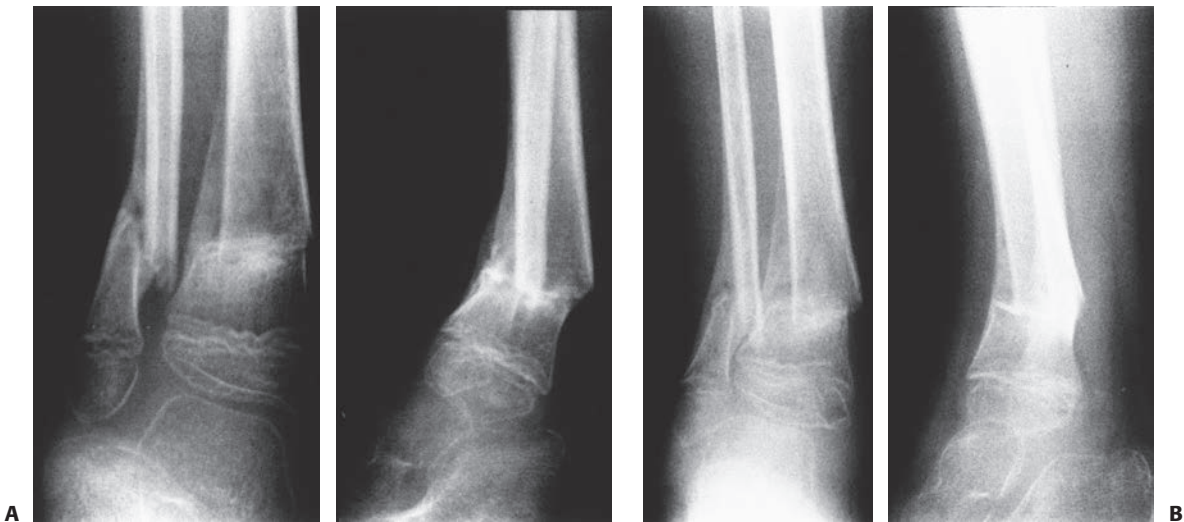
A: Anteroposterior and lateral radiographs 2 months after injury in a 6-year-old boy reveal a valgus and anterior malunion at the fracture. B: One year later, the child still has a moderate valgus and anterior malalignment of the distal fractured segment. This malalignment produced painful hyperextension of the knee at heel strike during ambulation.
